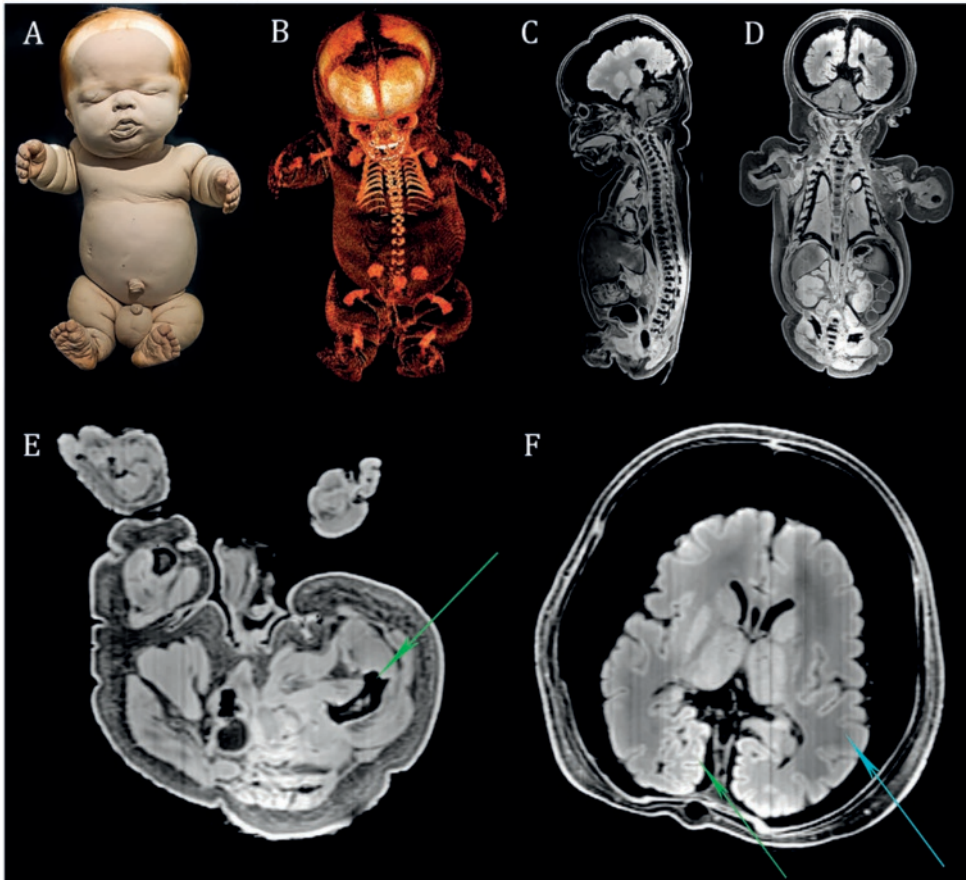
[A] Photograph of the full-term fetus of case 1. [B] 3D reconstructed skeleton based on the CT data. Although there was severely diminished bone calcification, CT images visualized extremely shortened ribs, short and small scapulae and iliac bones, and femoral and humeral bowing. [C] Sagittal T1-weighted MR image which showed a small foramen magnum with slight cranio-cervical caudal transition, platyspondyly of the vertebra with short vertebral arches resulting in spinal canal stenosis. [D] Coronal T1-weighted MR images showed a severely hypoplastic thorax with presumably severe lung-hypoplasia. [E] Transverse T1-weighted MR image on the level of the femoral heads showed broad and irregular metaphyseal plates and extreme femoral bowing (green arrow) sometimes referred to as ‘telephone receiver’ femora. [F] Transverse T1-weighted MR image of the brain which showed coarser gyri of the temporal lobes (turquoise arrow) and excessive gyration of the occipital lobes (green arrow) and can be interpreted as polymicrogyria. Note the shrunken brain and small lungs which were both interpreted as normal postmortem artifacts and probably strengthened by the formalin fixation. However, the presence of lung hypoplasia cannot be ruled out.
